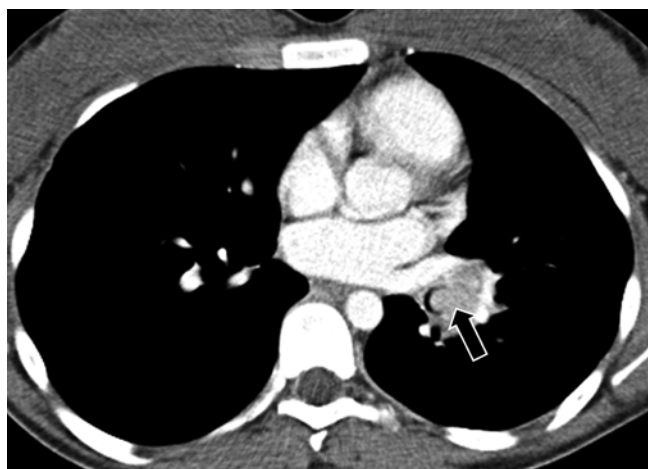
Endobronchial carcinoid tumor in a 16-year-old girl who presented with recurrent left lower lobe pneumonia for the last 3 years. Enhanced axial CT image shows an intraluminal mass (*arrow*) involving the left lower lobe bronchus
